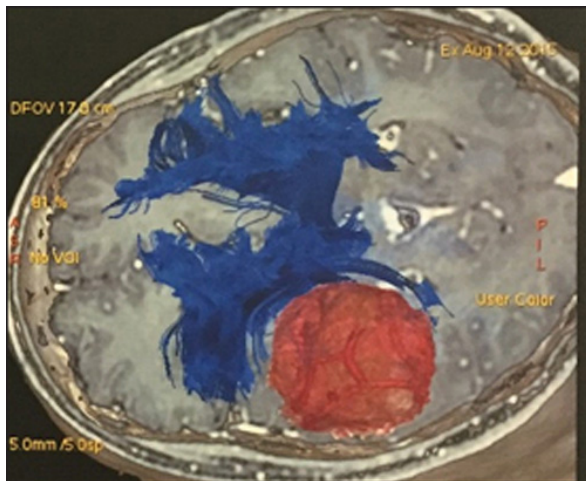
Tractography magnetic resonance imaging. In blue: the white fibers tracts. In red: tumor
